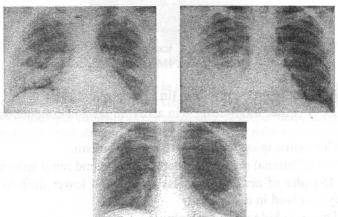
Chest X-ray of IVDU patient Z., 23 years with right heart IE. Multiple infiltration and signs of destruction.
